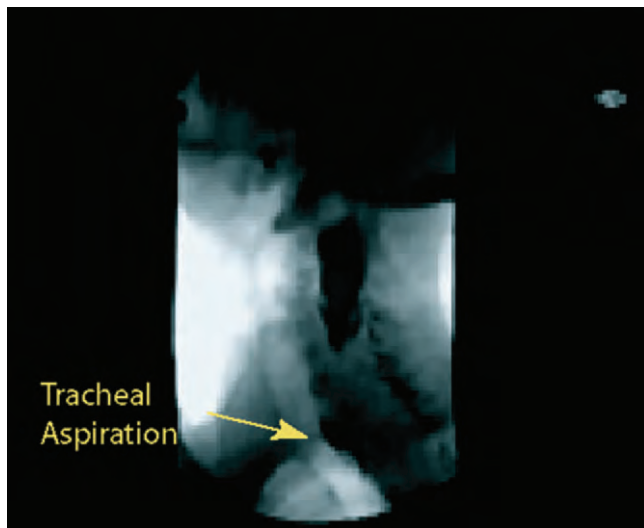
Barium contrast roentgenogram from a patient with cricopharyngeal achalasia and poor upper esophageal sphincter opening. There is significant retention of contrast medium at the level of the vallecula and piriform recesses, with no barium passing into the esophagus. The patient also shows significant aspiration of contrast into the trachea (yellow arrow).
